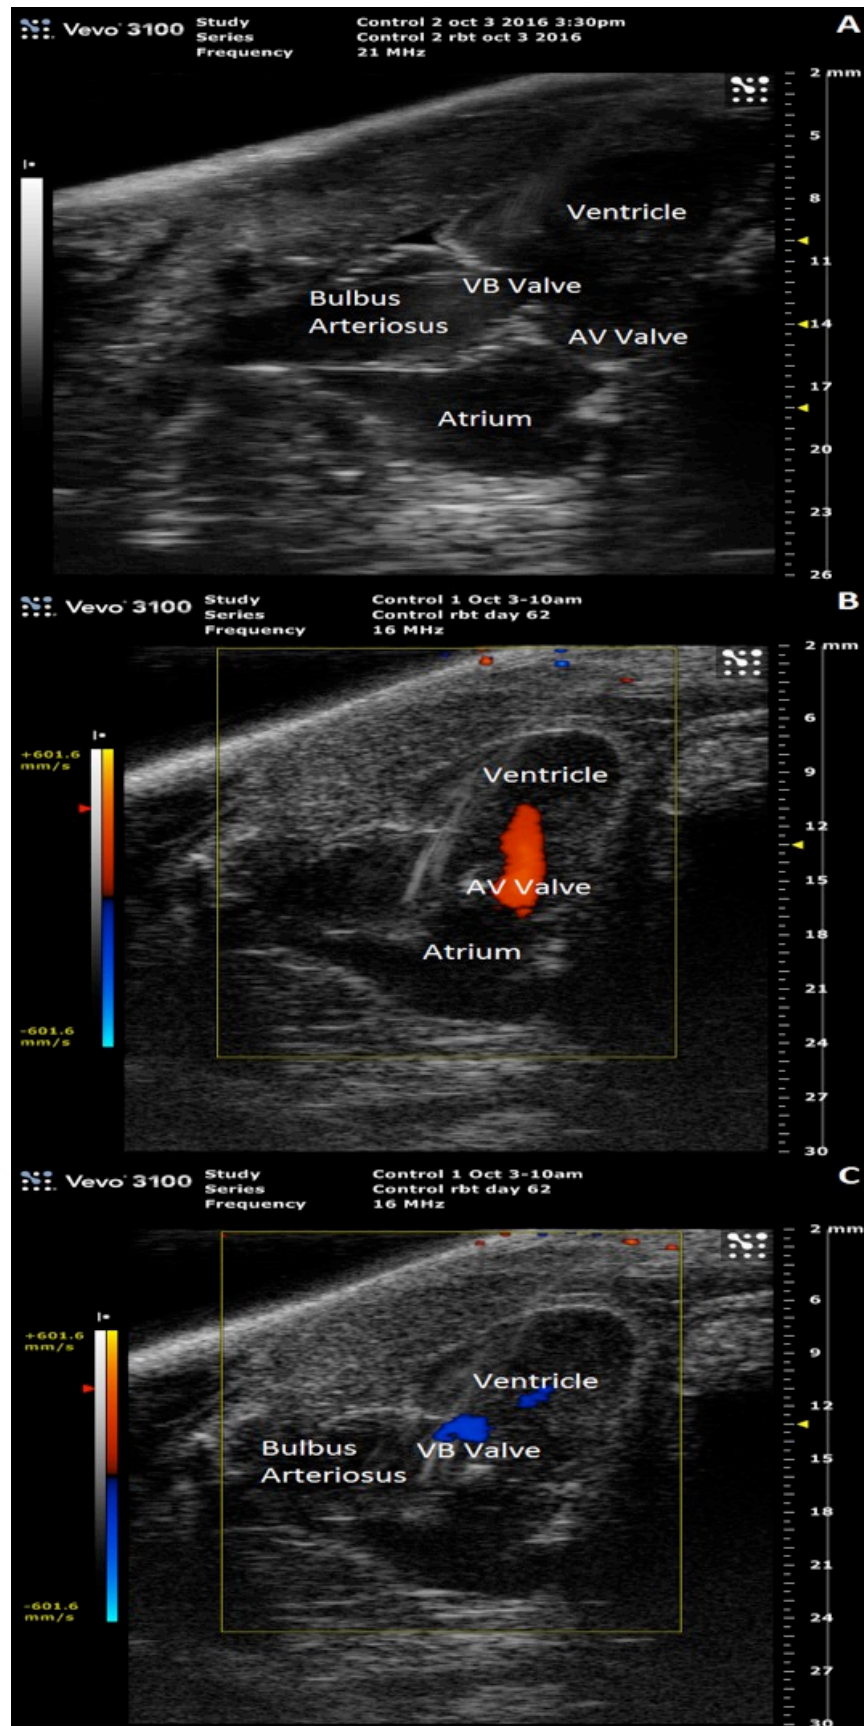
Representative long-axis brightness mode (B-mode) and colour flow Doppler short-axis views of the juvenile rainbow trout heart. Anesthetized control trout are imaged ventral side up, with B-mode showing general cardiac structures indicated by labelled arrows in panel A (AV = atrioventricular valve; VB = ventriculobulbar valve). Blood flow direction and velocity are indicated by colour in panel B, with red indicating a slow to moderate speed with unidirectional flow from atrium to ventricle through the atrioventricular valve using colour flow Doppler mode. Panel C shows blood flow through the ventriculobulbar valve.
